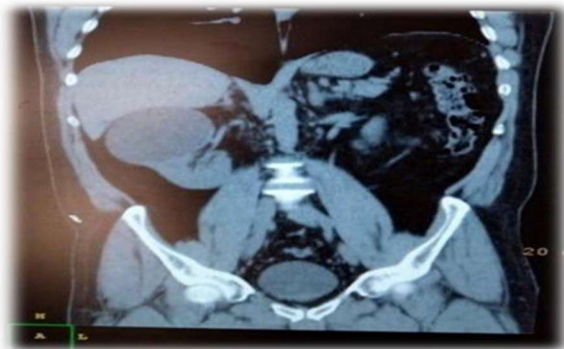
shows a coronal CT scan showing a demonstrating 8 cm complex cyst of the right kidney
